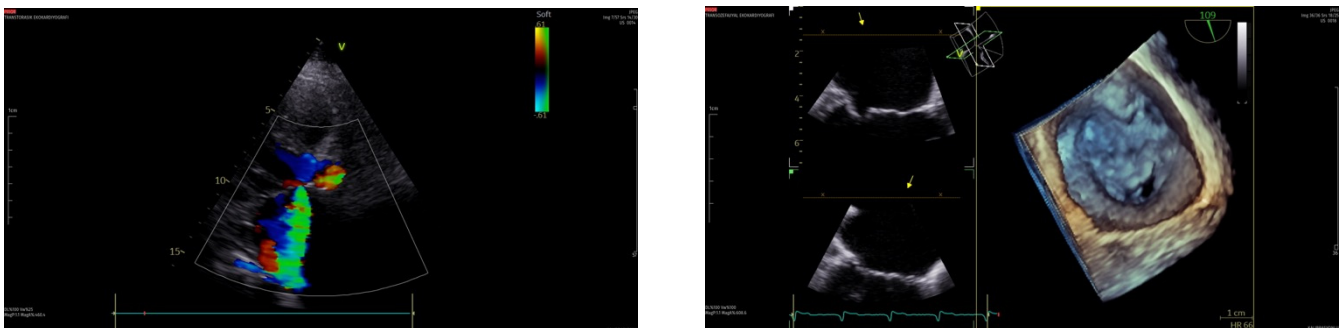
(a) Mitral regurgitation flow seen due to a perforation of the anterior mitral leaflet on transthoracic echocardiography, (b) 3-dimensional transesophageal echocardiography showing the perforation on A2 mitral leaflet scallop (red arrows).
